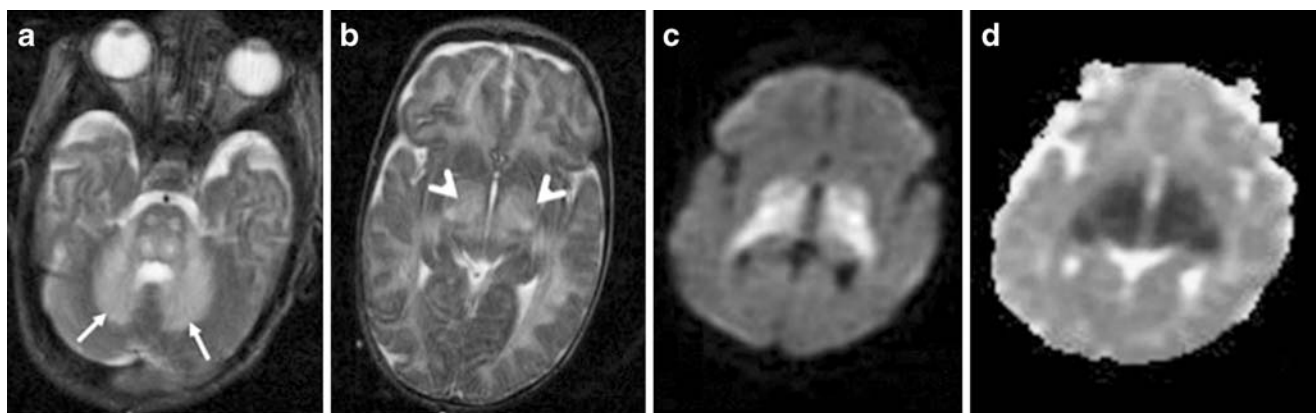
A 1-month-old infant girl with MSUD. a, b Axial T2-W images through the cerebellum and at sylvian fissure level show hyperintensity in (a) both dentate nuclei (*white arrows*) and cerebellar white matter, (b) the thalami (*arrowheads*) and white matter. c DWI
